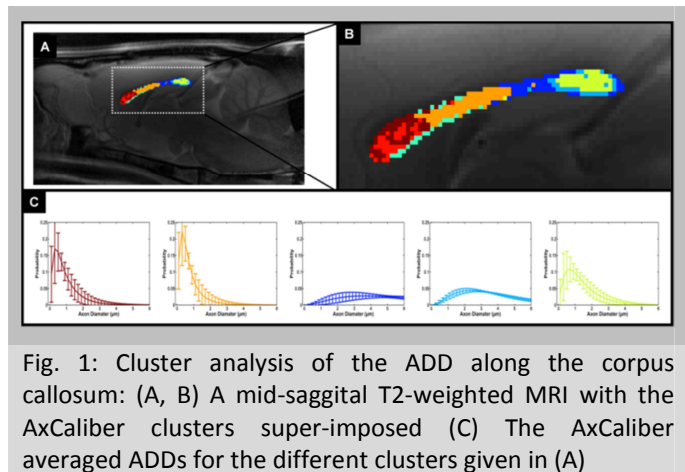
Cluster analysis of the ADD along the corpus callosum: (A, B) A mid-sagittal T2-weighted MRI with the AxCaliber clusters super-imposed (C) The AxCaliber averaged ADDs for the different clusters given in (A)
